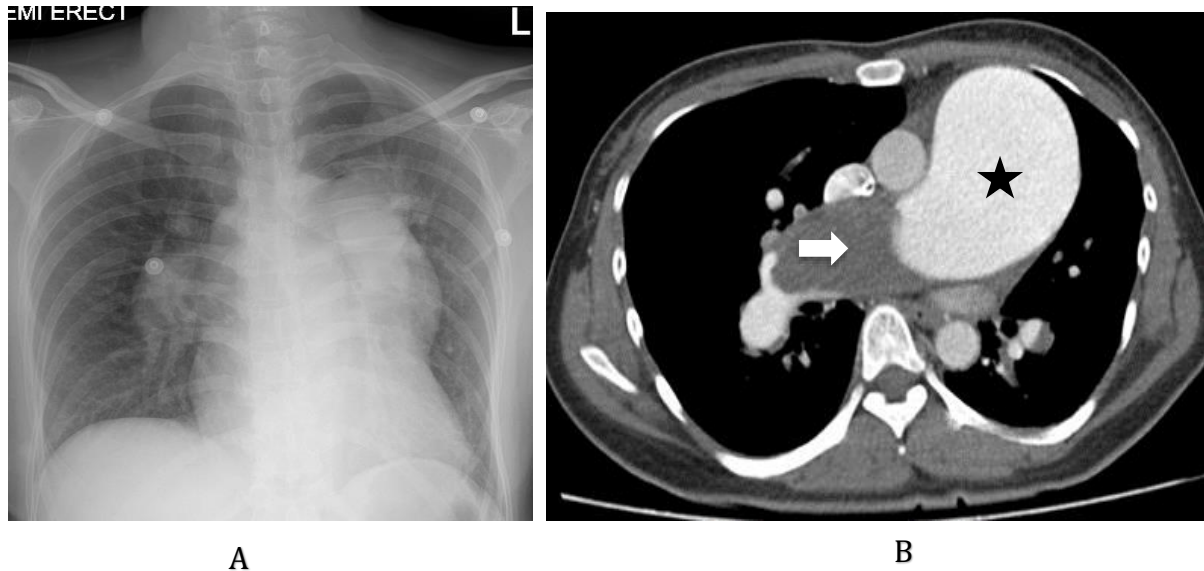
(A) Enlarged bilateral main pulmonary arteries with pruning of peripheral vessels. (B): CT pulmonary angiography (CTPA) shows grossly dilated pulmonary trunk (★) and large thrombus in right main pulmonary artery (white arrow)
